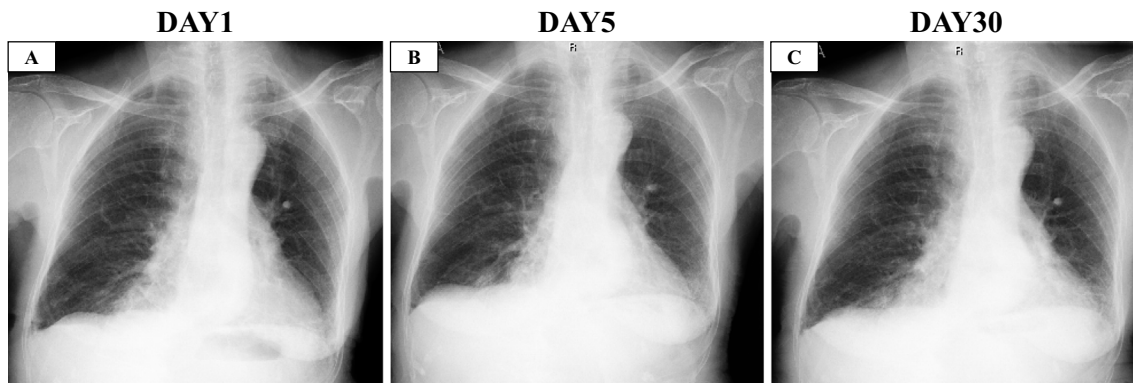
Chest X-ray images. A: On the day of admission to our hospital. B: On the day of the initiation of steroid therapy (five days after admission). C: Two weeks after the initiation of steroids.
